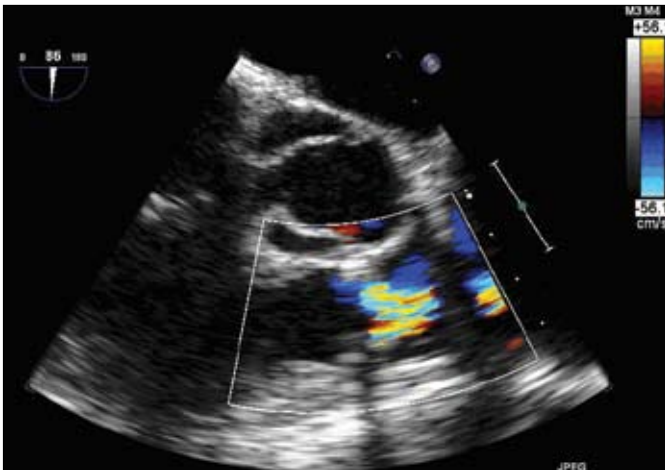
Color-flow Doppler across the pulmonic valve showing highly turbulent flow secondary to the stenotic orifice.
